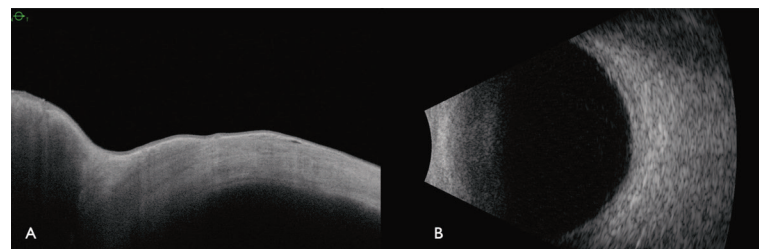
(A) Anterior segment OCT and (B) B-scan ultrasonography of the left eye with normal findings.
